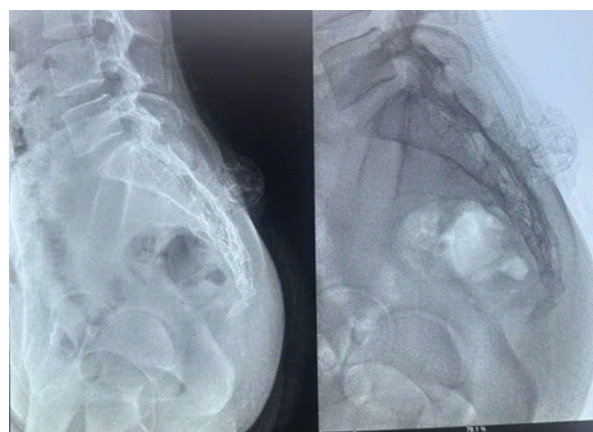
Lateral radiographs showing a cauliflower like bony outgrowth.
